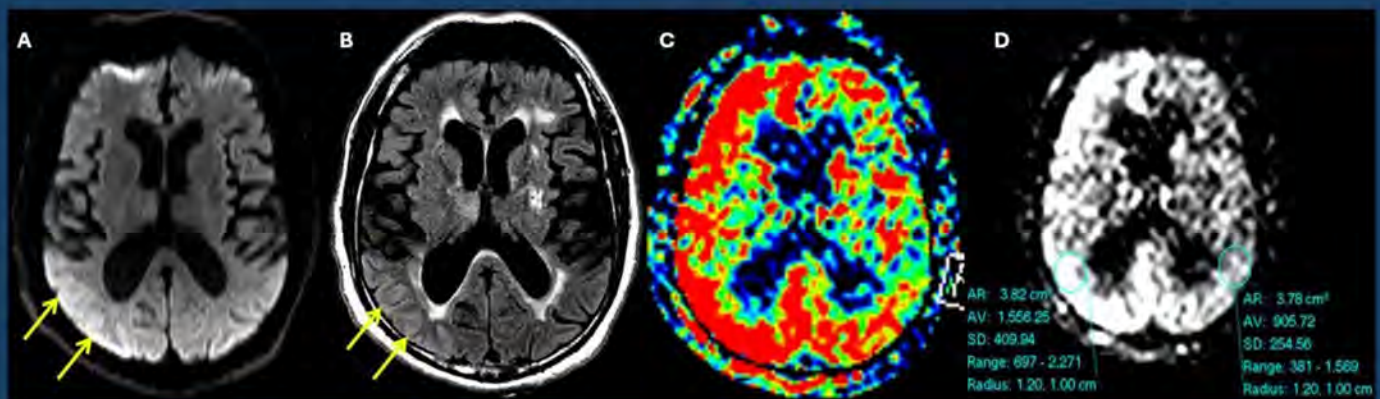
A 64yo male patient presented with status epilepticus. Axial DWI (A) and FLAIR (B) images show right parieto-occipital cortical restricted diffusion with corresponding FLAIR hyperintensity. Axial colored ASL map (C) shows diffuse increased perfusion over the right cerebral hemisphere. ASL-rCBF map (D) reveals hyperemia of the right cerebral hemisphere compared to the left one, evidenced by both qualitative and quantitative evaluation. EEG revealed severe cerebral disturbance over the right cerebral hemisphere, consistent with the perfusion abnormality detected on ASL.
